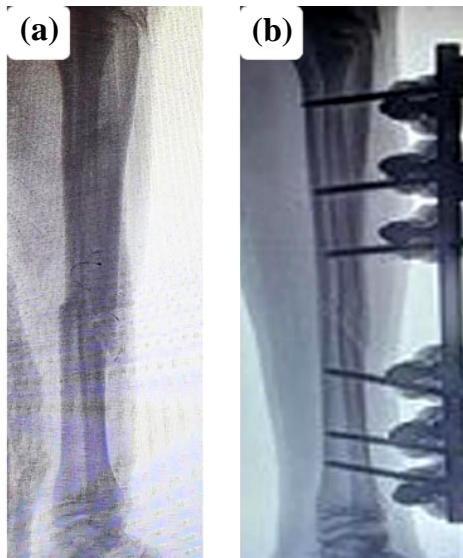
a) Pre-operative, and b) Post-operative X-rays of the tibia.
